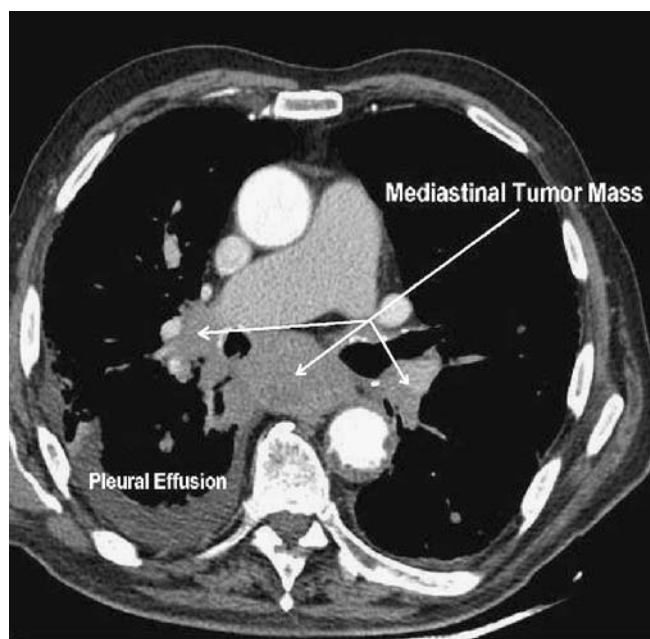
CT scan of the chest showing a mass in the mediastinum and a small pleura effusion of the right lung
